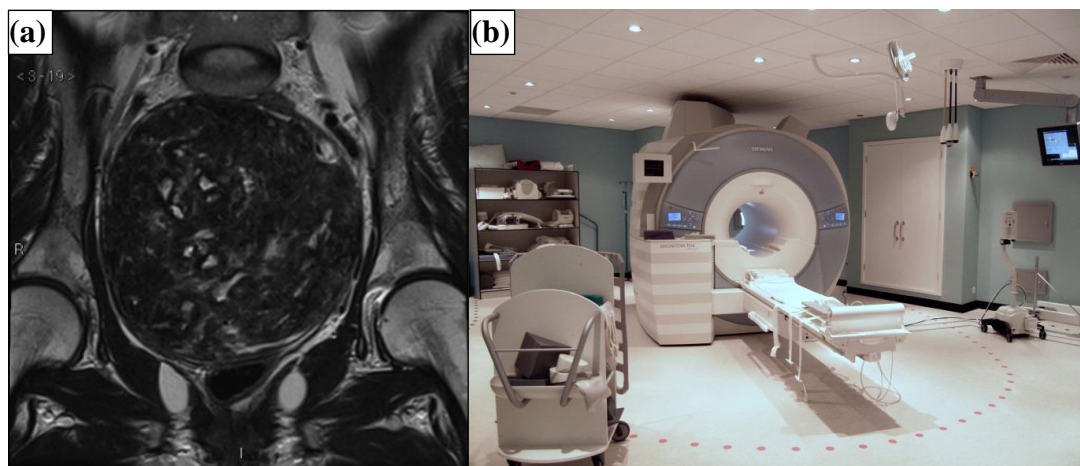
(a) Example of Magnetic Resonance Image (MRI) (image of pelvis showing uterine fibroid on T2 weighting). (b) MRI room at the Clinical Research Centre (CRC), Ninewells Hospital (Dundee, UK).
